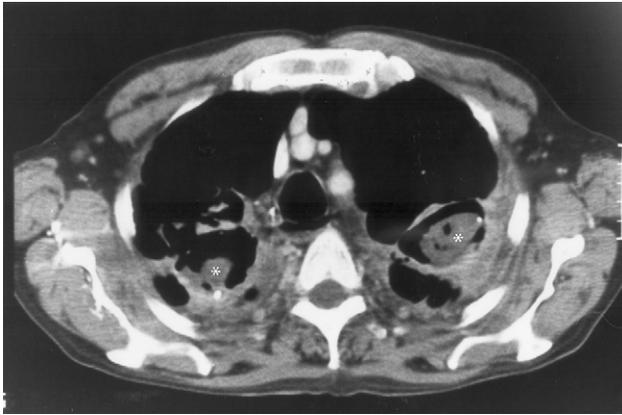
Aspergillomas in a 52-year-old man with hemoptysis. Chest CT image (soft tissue window) reveals a single, rounded, low-attenuation mass (asterisks) within the dependent portion of a cyst within the apical portion of each upper lobe. The mass on the left shows internal air lucencies. The cyst walls are thickened along the portion contacting pleura. Surgery proved that both masses were aspergilloma.
